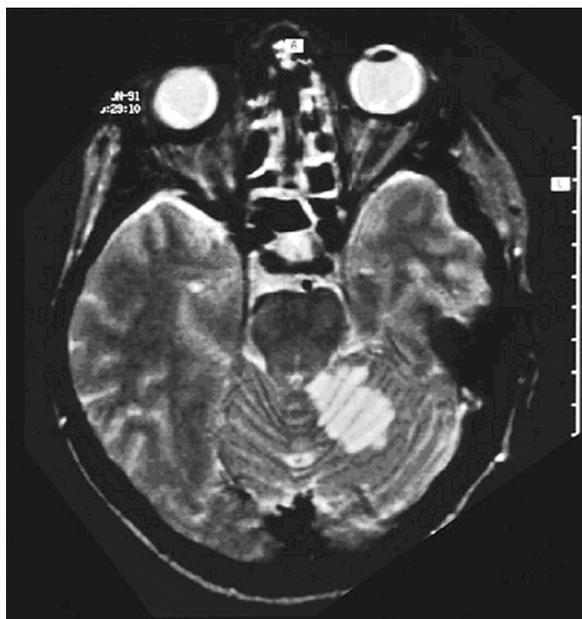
An ischemic stroke in the territory of SCA (MRI T2-weighted imaging).
